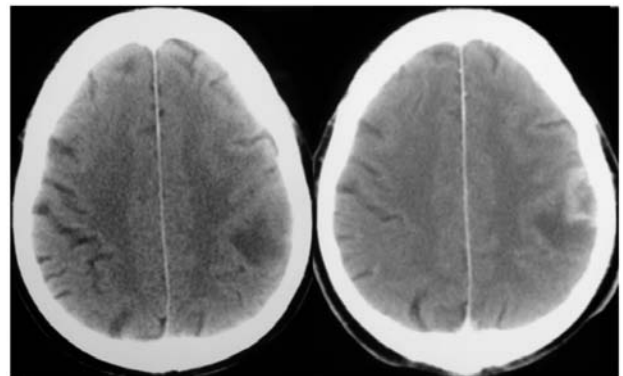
CT scan displaying an isodense lesion with marked peripheral edema in the left frontal region (left). Peripheral enhancement of the lesion was observed after contrast medium injection (right)
